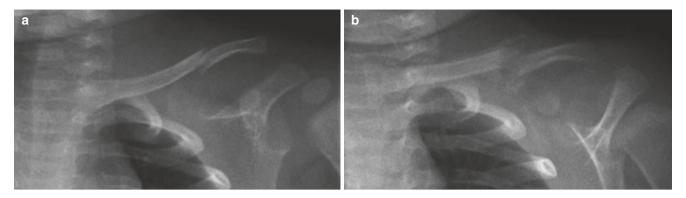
(a) Non-displaced oblique mid-shaft clavicular fracture in a child after a fall from a chair. (b) Radiograph after 17 days shows soft callus formation
